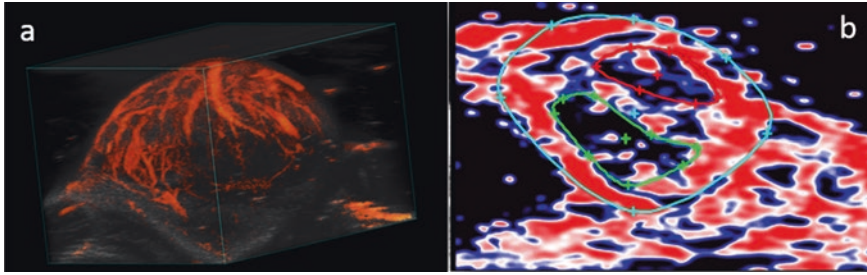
(a) 3D Power Doppler image (orange colour) of the tumour overlaid on the ultrasound image (grey). (b) 2D parametric map of oxygen saturation where red represents the highly oxygenated regions and blue represents the low oxygenated regions of the tumour
